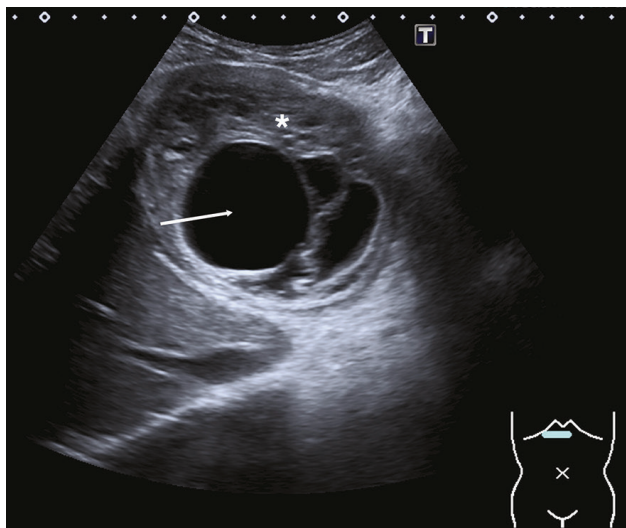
Abdominal ultrasound in a 27-year-old patient with pain in the epigastric region of several days' duration shows a focal lesion of heterogeneous appearance in the left lobe of the liver, with echogenic areas of solid (asterisk) and cystic (white arrow) appearance inside. Gharbi type IV-CE4.
